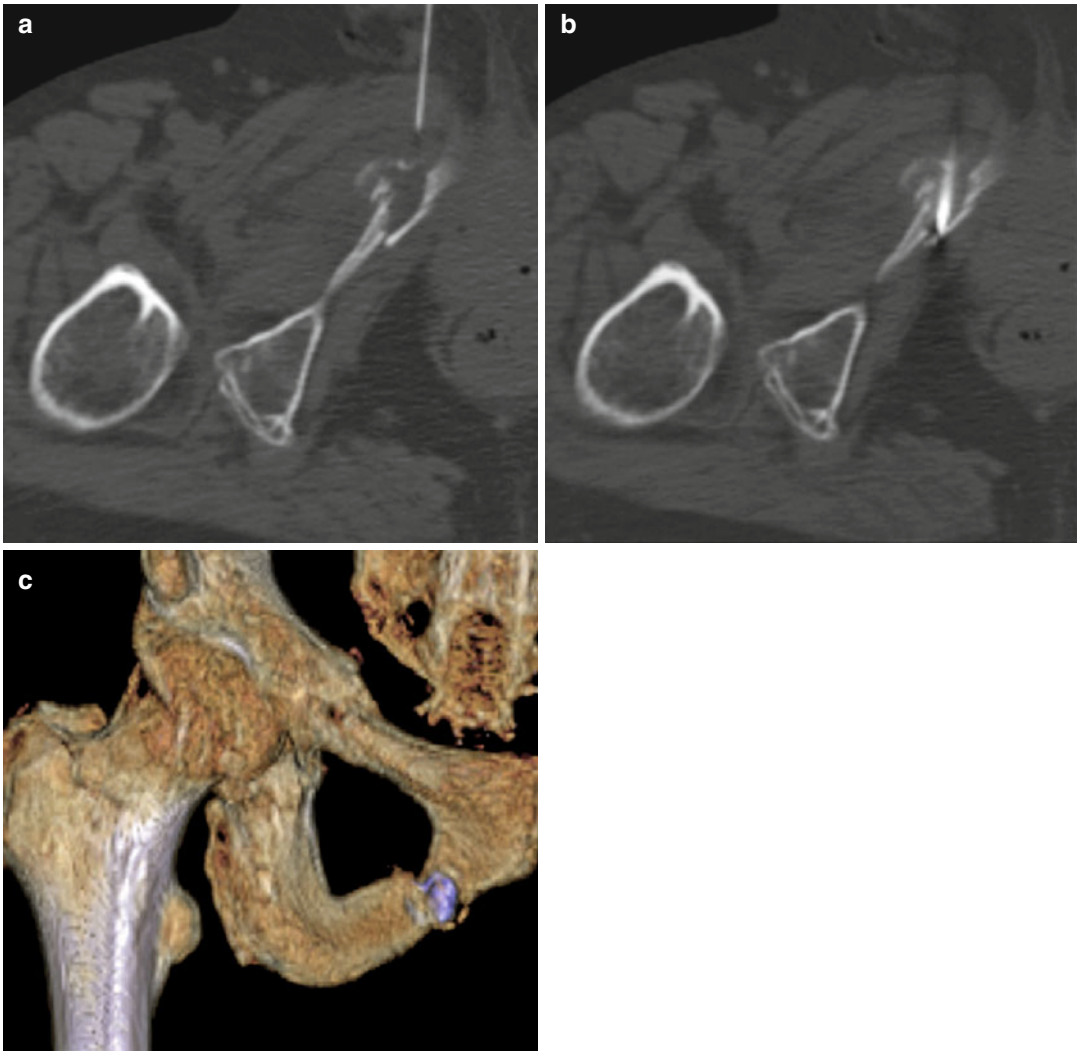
(a–c) Osteoplasty: axial CT scan of the pelvis shows painful osteolytic lesion of the right pubic bone associated with pathologic fracture (a). A 22-Gauge needle for local anesthesia is placed under CT guidance (b). An 11-Gauge trocar bone biopsy needle is inserted. CT
